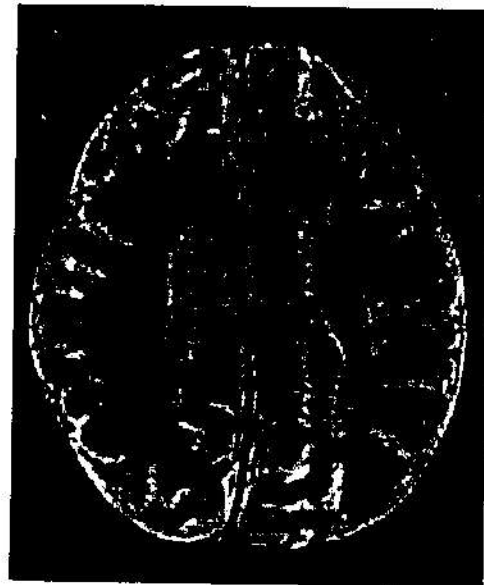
Two T<sub>2</sub>-weighted MR images of 26-month-old INCL patient, showing severe atrophic changes: ventricles and sulci large and splenium poorly visible; white matter has higher signal intensity than grey matter, which is reverse of normal relationship at this age; periventricular white matter is the most intense, and intensity loss of basal ganglia and thalamus is remarkable.
